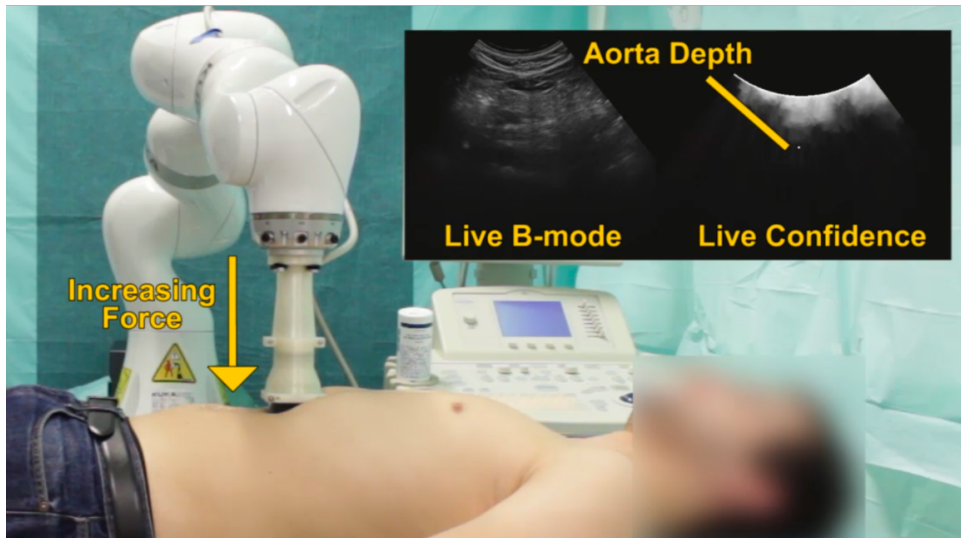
The presented system autonomously selects the best suitable force to apply onto the patient surface to achieve an optimal visibility of the target anatomy. On the top left the live ultrasound image acquired by the robot is shown, together with its respective confidence map. The average confidence value around the aortic region is used as input for the used force control strategy.
